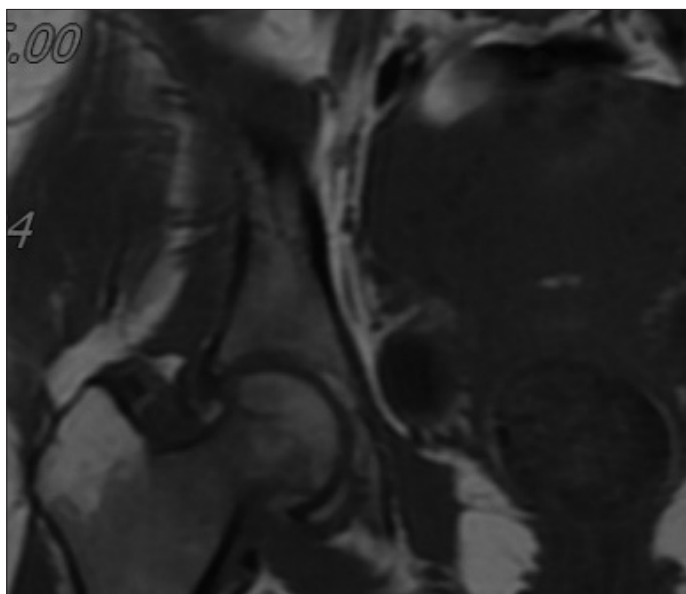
Preoperative magnetic resonance image of the left hip
